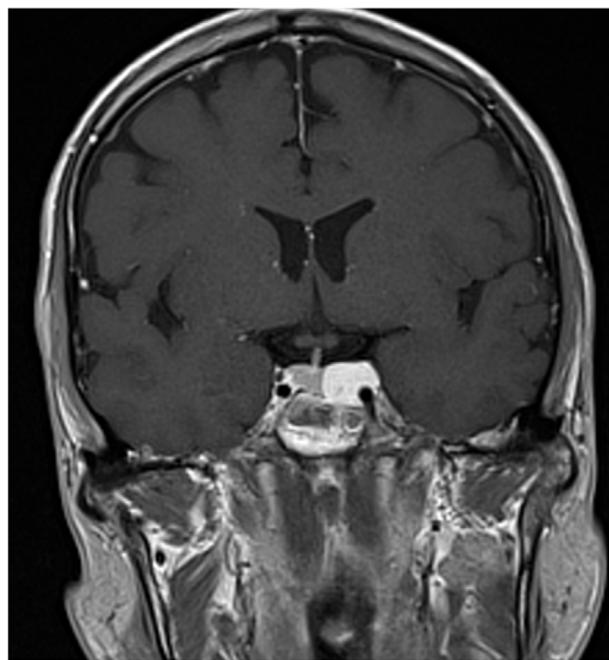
Postoperative coronal T1-weighted magnetic resonance (MR) presenting tumour mass localised mainly in the left cavernous sinus with normal pituitary gland constriction. Intense, homogeneous contrast enhancement is seen.
